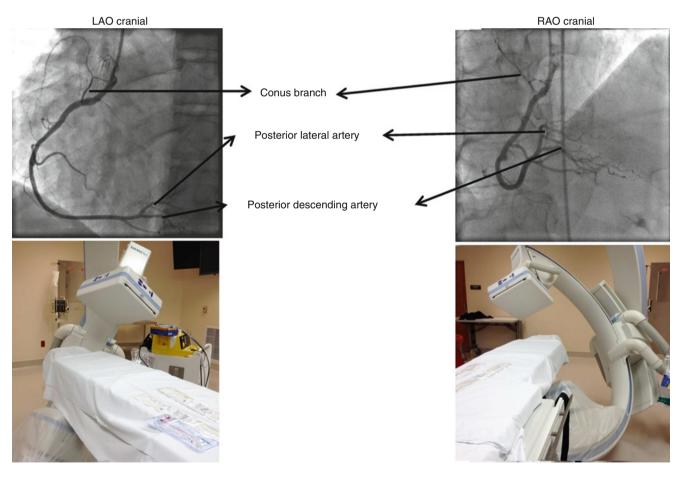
Angiographic views of the right coronary artery (*RCA*). The approximate positions of the x-ray tube and image intensifier are shown for each of the commonly used angiographic views
